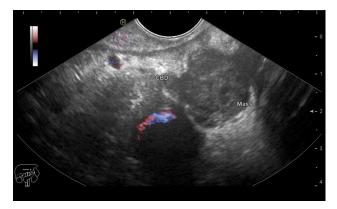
Endoscopic ultrasound images demonstrate the mass/ enlarged lymph nodes at the liver hilum com-pressing the common bile duct. CBD: common bile duct.
